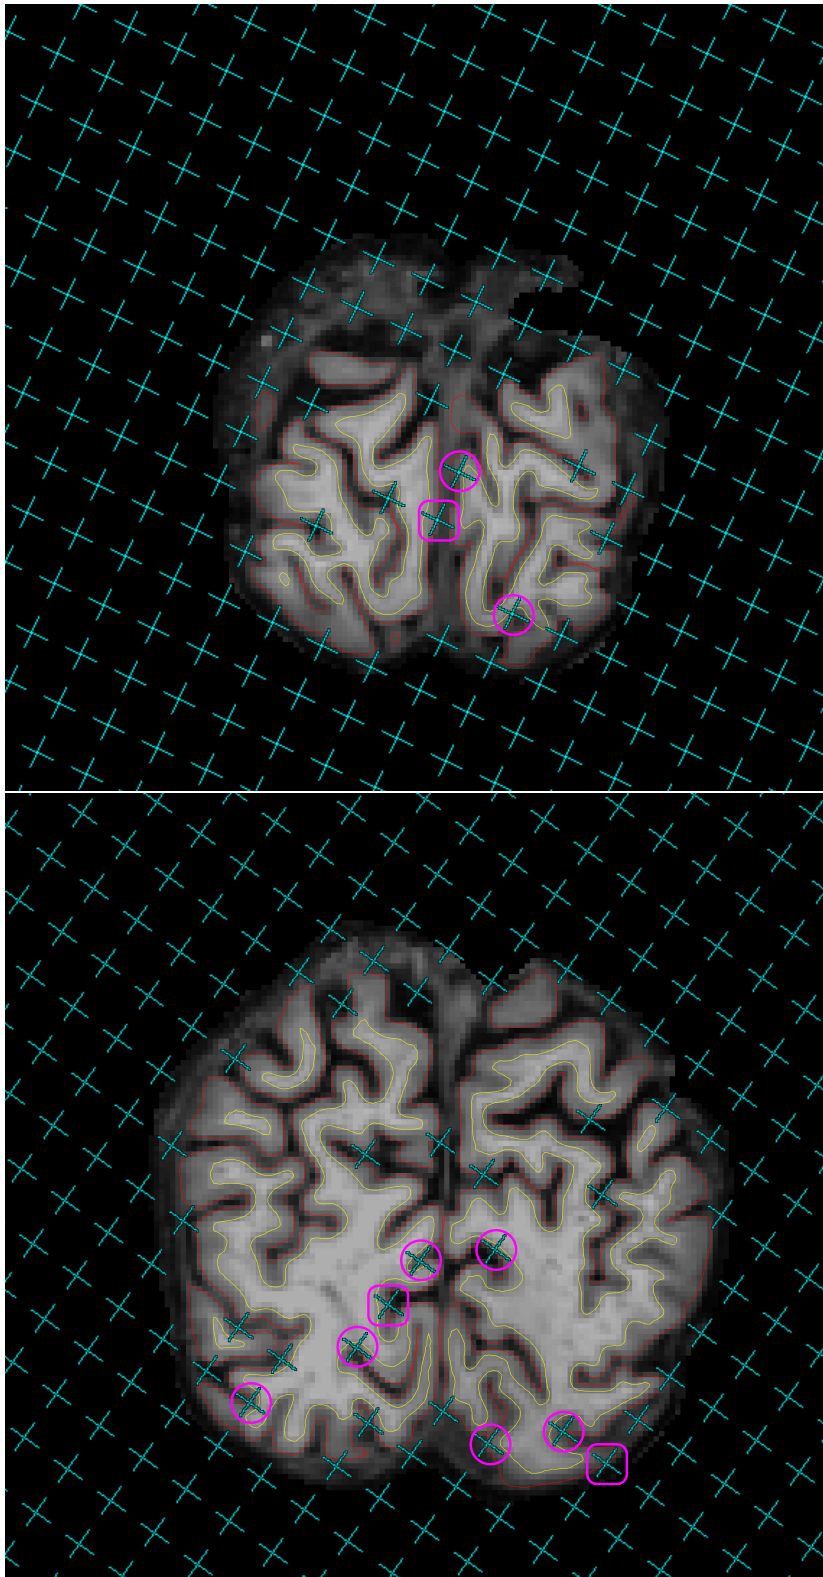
On the 2nd and 3rd slices of one brain MR image in the coronal view, uncounted test points (cyan) which miss the cerebral parenchyma or hit the ventricles are overlaid onto pial profiles (red lines) segmented by FREESURFER. Circles (pink) mark the uncounted test points which fall inside the grey matter boundaries (red lines) and rounded rectangles (pink, racetrack-like) mark the test points hitting exactly on the grey matter boundaries.
